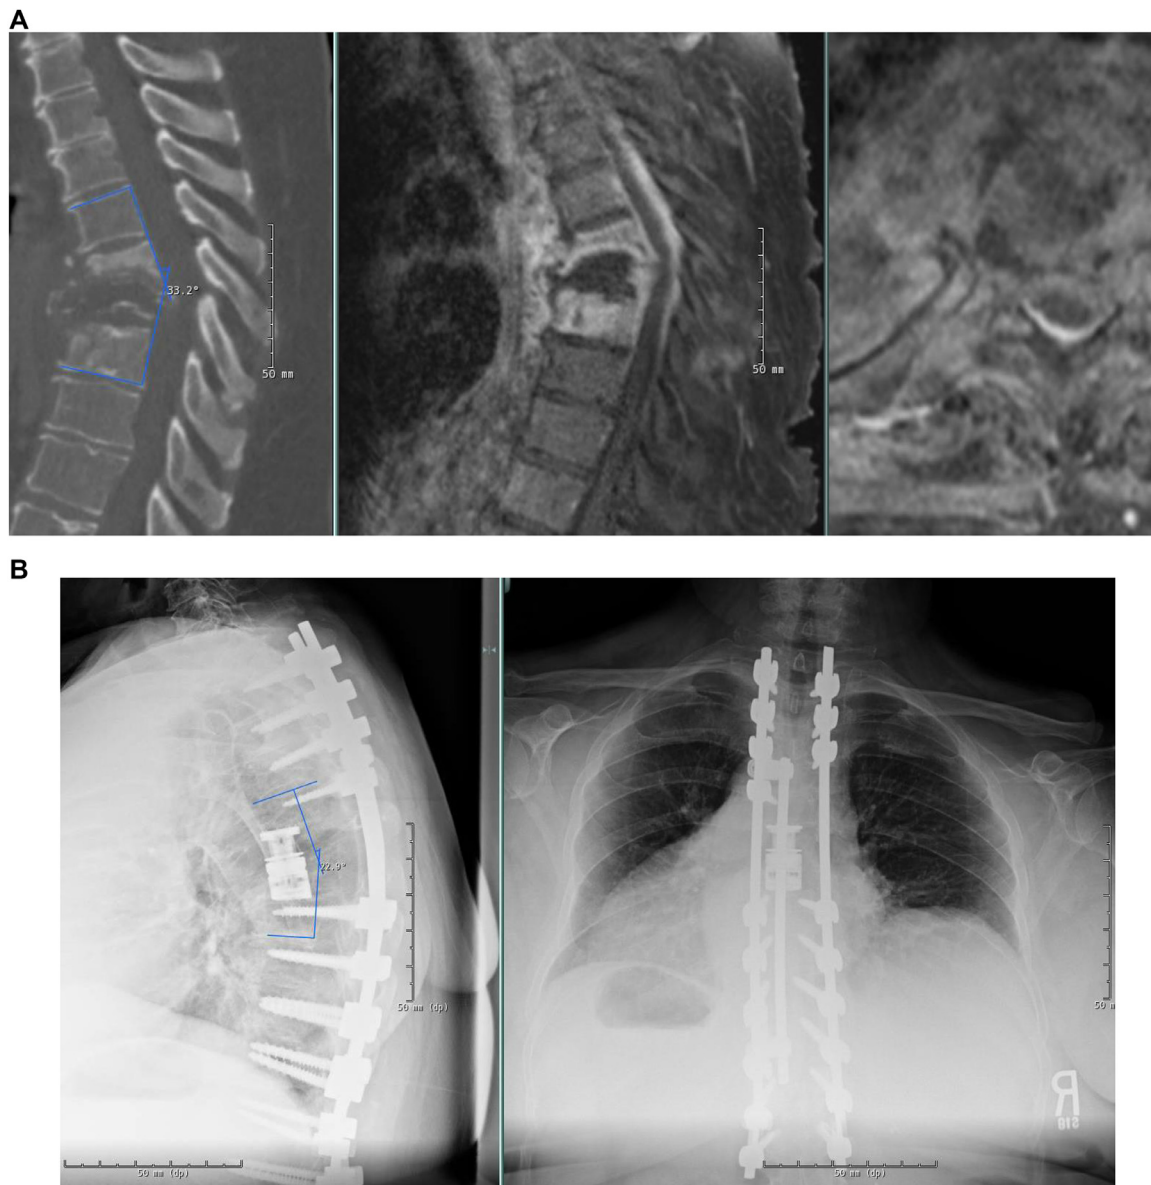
A 65-year-old female presented with refractory back pain after being treated for T7–T8 osteomyelitis/discitis with intravenous antibiotics. She has a history of uncontrolled diabetes mellitus. She also has multiple skin lesions due to scratching secondary to pruritis from narcotic use. She was unable to ambulate due to a combination of pain and myelopathy. She underwent a T7 and T8 vertebrectomy, multilevel posterior column osteotomies, placement of a T6–T9 expandable intervertebral titanium spacer, and a T3–L2 posterolateral fusion. Following the surgery, she was able to ambulate and had significant improvement in her pain. (A) Preoperative computed tomography (lateral) and magnetic resonance imaging (T1-weighted sagittal and axial) demonstrates destruction of the T7 and T8 vertebral bodies, epidural abscess, and focal kyphosis measuring more than 30 degrees. (B) Follow-up AP and lateral radiographs demonstrate improvement in the focal segmental deformity.
